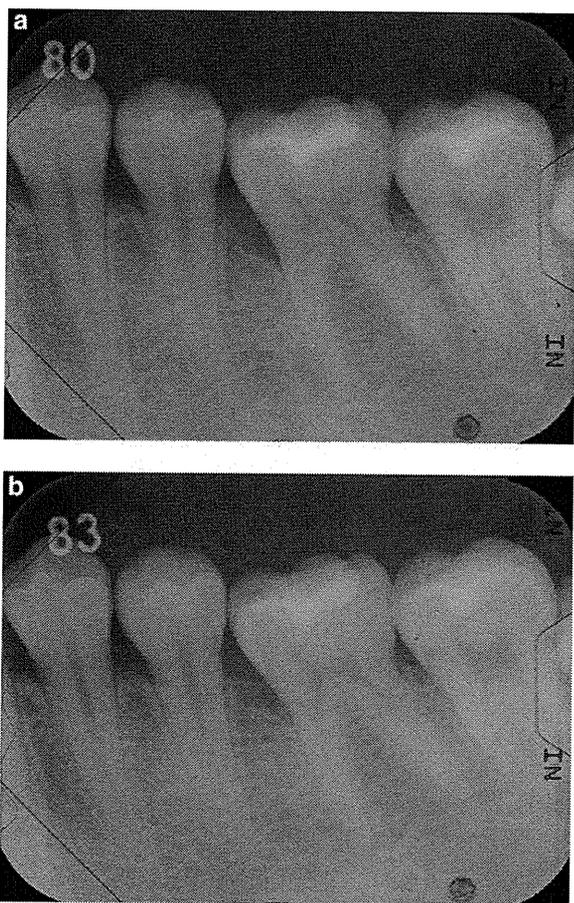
Case 1. Standardized dental radiograph before administration. 1b 36 weeks after administration of 0.3% FGF-2.
